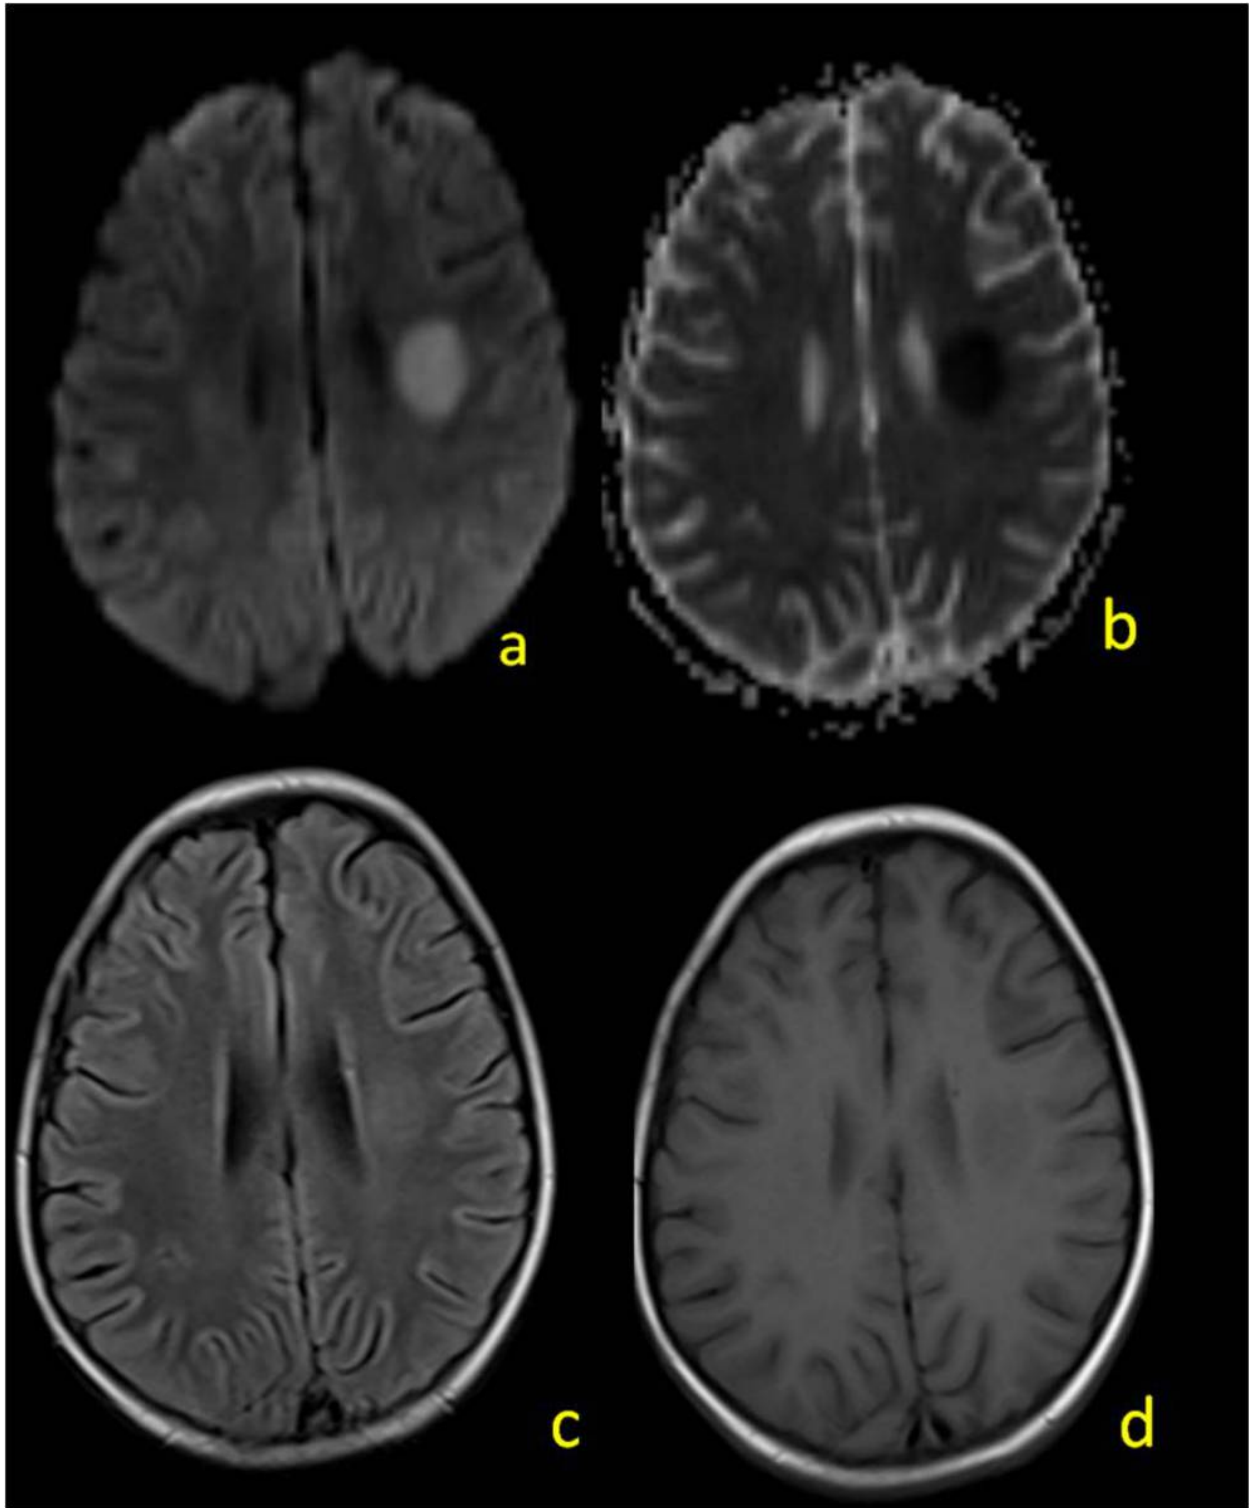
5 year old male patient with AML presented 11 days following intrathecal methotrexate with severe headache, initial MRI study show areas of restricted diffusion with reduced ADC value at the left centrum semiovale (Fig. a&b). No definite abnormalities could be detected at the FLAIR and T1WI images.(Fig. c&d).
